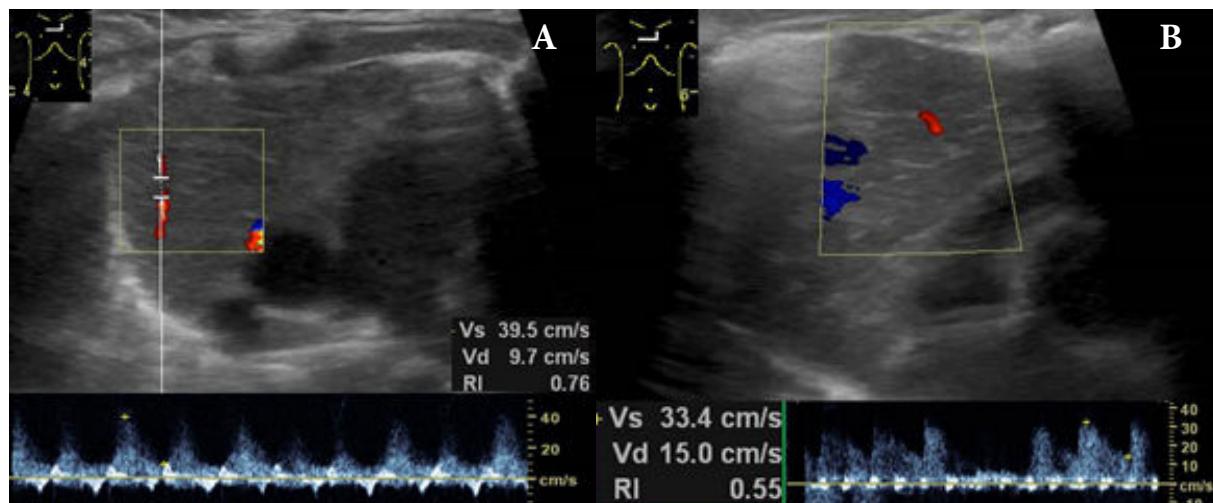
Color Doppler sonography of normal thymus in a 2-month-old boy (A) and another 4-month-old boy (B) revealed a few intra-thymic artery with low-resistant waveform.
